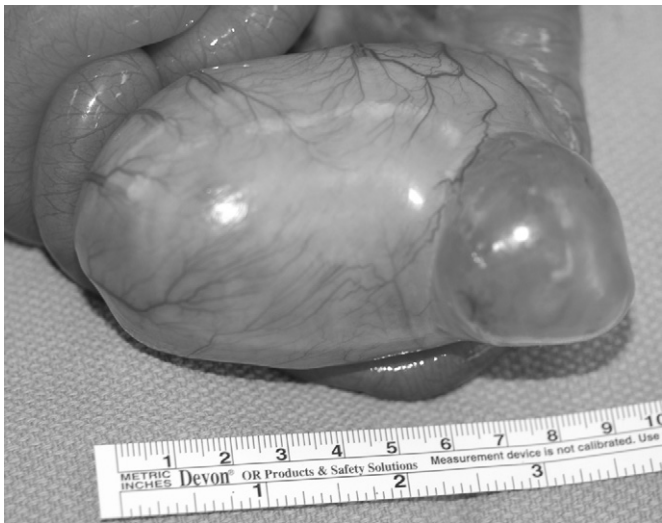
This cystic duplication of the ileum with the adjacent 5 cm of bowel was resected from a 2-month-old girl. Intestinal continuity was reestablished with a primary anastomosis. This mass was diagnosed on prenatal ultrasonography.
